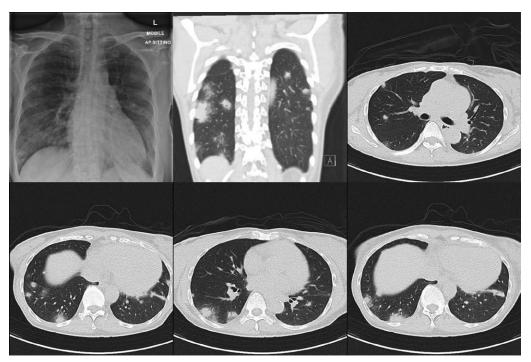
Chest radiograph and computer tomography images (on admission).
